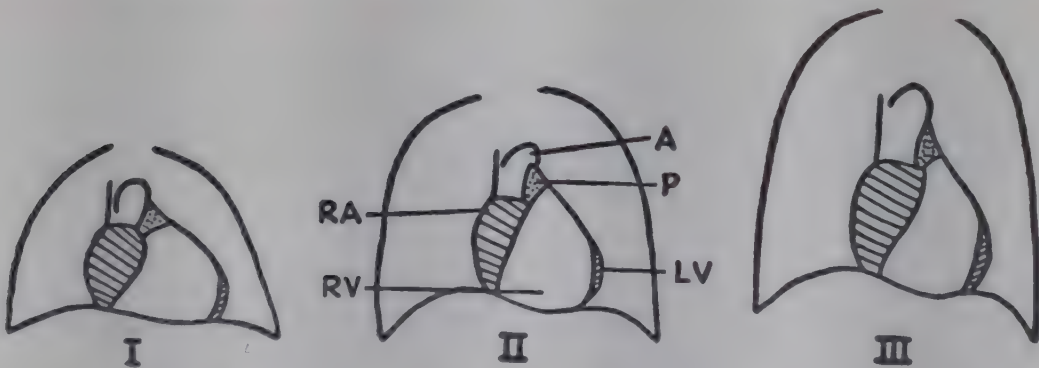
The cardiac shadow at different ages as seen by roentgenography in the anteroposterior position. *I*, early infancy; *II*, 4 year old child; *III*, adult. *RA*, right auricle; *RV*, right ventricle; *A*, aorta; *P*, pulmonary conus; *LV*, left ventricle.
